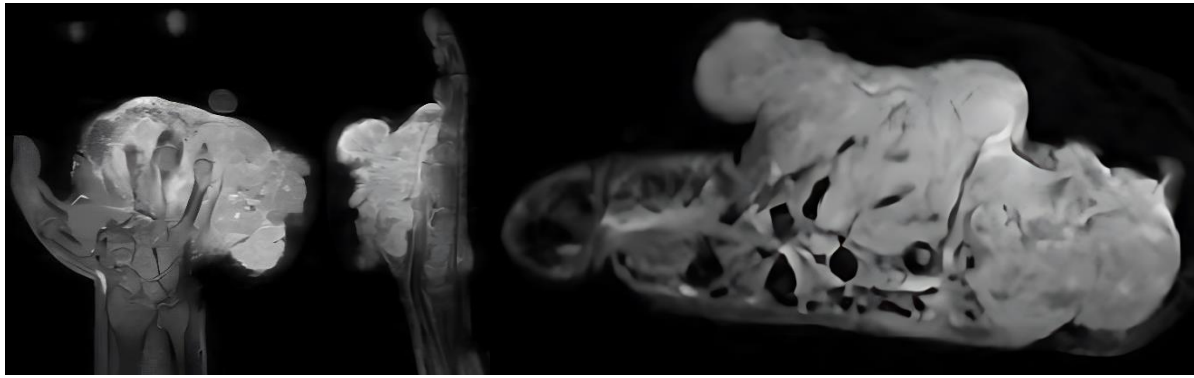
MRI. (A) Coronal section; (B) Sagittal section; (C) Axial section. A malignant soft tissue mass in the left-hand region caused deformity of the fifth metacarpal bone to the middle phalangeal bone of the fifth digit of the left hand and infiltrated the left abductor digiti minimi muscle, left opponens digiti minimi (ODM) muscle, left flexor digiti minimi (FDM) brevis muscle, left palmar muscle, left lumbrical muscle, left palmar interossei muscle, and left dorsal interossei muscle with the impression of receiving feeding from the left ulnar artery and left radial artery and accompanied by bone marrow replacement in the 4th-5th metacarpal bone of the left hand.
